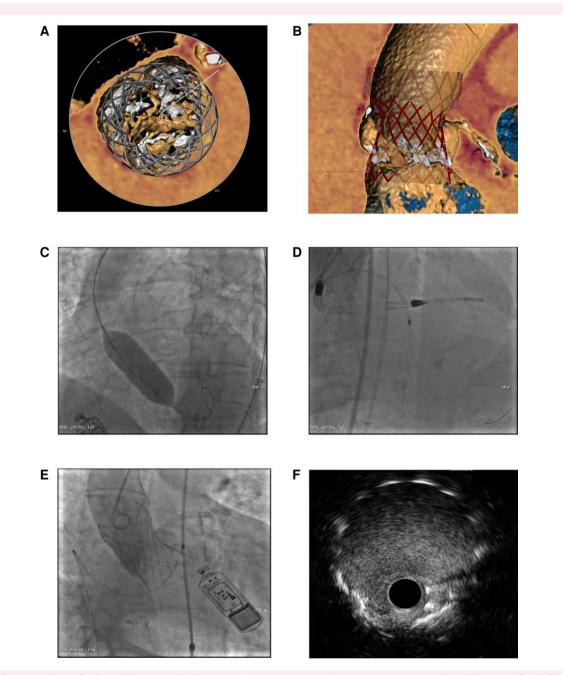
Summary of case 2. (A and B) Pre-procedural computed tomography scan showing severe aortic valve calcification; a Evolut PRO model is superimposed on the computed tomography scan suggesting coronary ostia covered by stent frames and possible difficult coronary access after transcatheter aortic valve implantation. (*C*) Upfront balloon aortic valvuloplasty to allow circulatory support with Impella; (*D*) Impella support is in place and complex percutaneous coronary intervention with rotational atherectomy of left main-left anterior descending artery axis is commenced; (*E*) Evolut PRO is placed after percutaneous coronary intervention; (*F*) final intravascular ultrasound result showing optimal stent expansion and apposition and adequate minimal stent area on the left main-left anterior descending artery axis.
